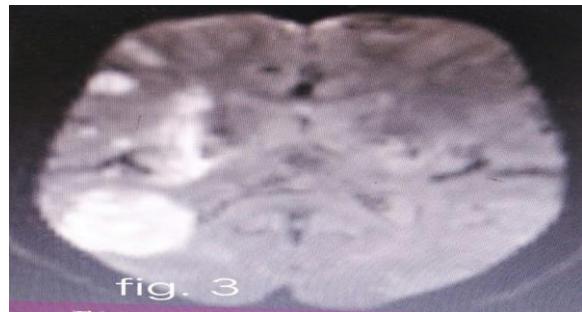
MRI brain revealed diffusion restricted lesion.
